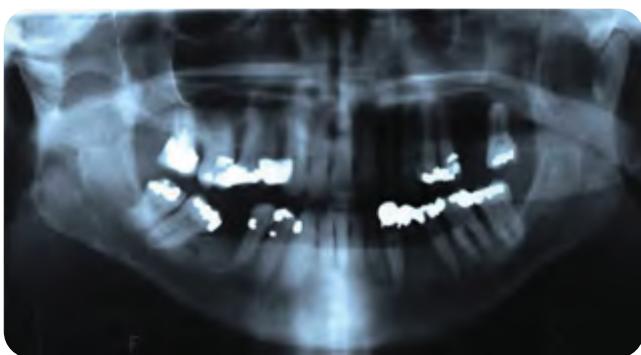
A.2. A panoramic radiograph in addition to the clinical TMJ exam and history can add important information to the diagnosis and treatment plan.
